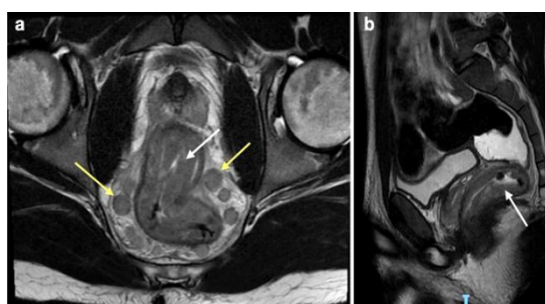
MRI. A. Axial section. B. Sagittal section. Rectal parietal thickening (white arrows) and mesorectal enlarged lymph nodes (yellow arrows).
